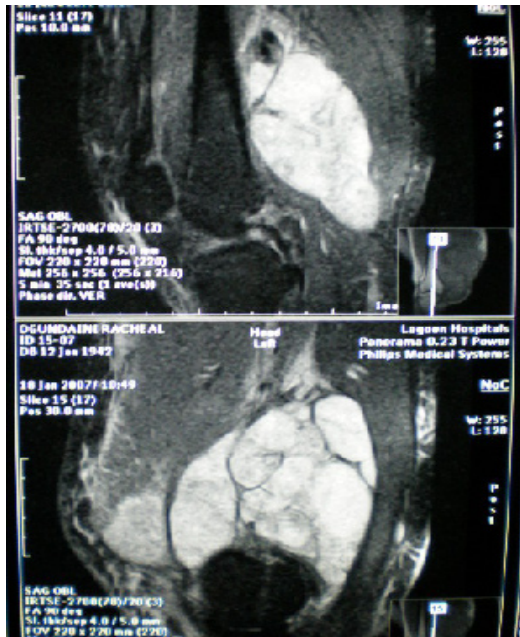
MRI picture showing the tumour encasing the popliteal vessels.
